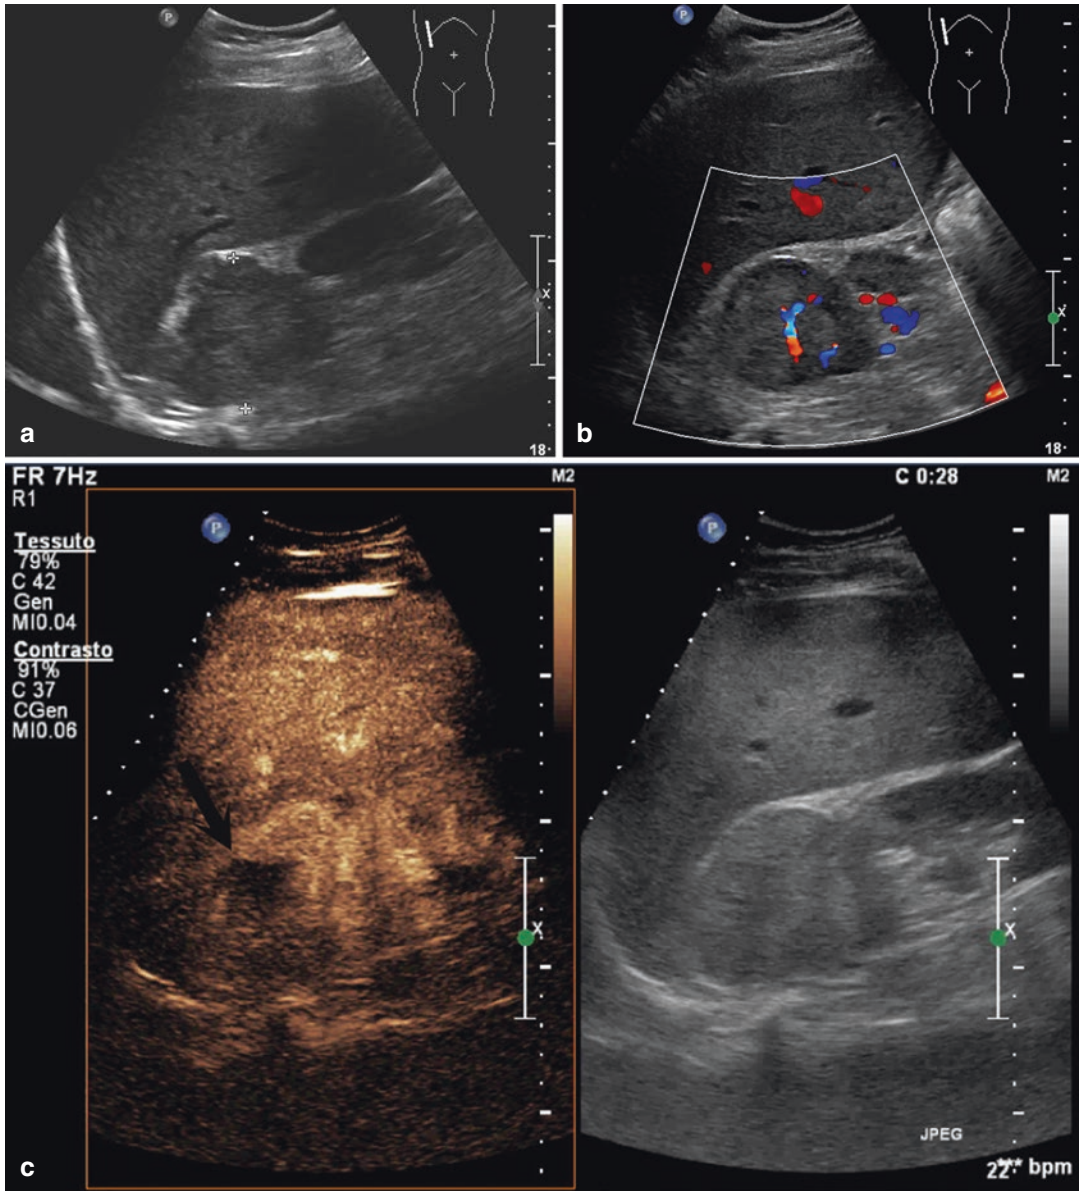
Large mass of the right kidney (a) with central vessel at color Doppler (b). After contrast injection, there is a strong enhancement with depiction of a central scar (black arrow), suggestive of oncocytoma (surgery confirmed) (c)
